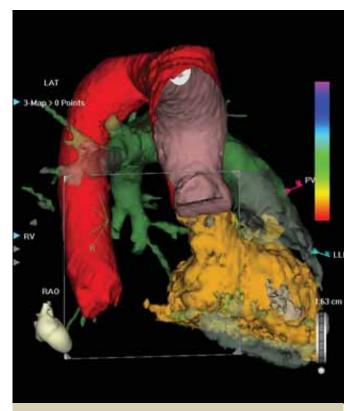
A reconstructed CT scan using CARTO Merge software. The software has assigned different colours to different chambers. In this case the left ventricle is yellow, the aorta red, and the right ventricular outflow tract (RVOT) and pulmonary artery are green. This image shows how the left ventricular outflow tract starts on the left side of the RVOT and curls behind it to end up on the right side of the pulmonary valve and main pulmonary artery.
